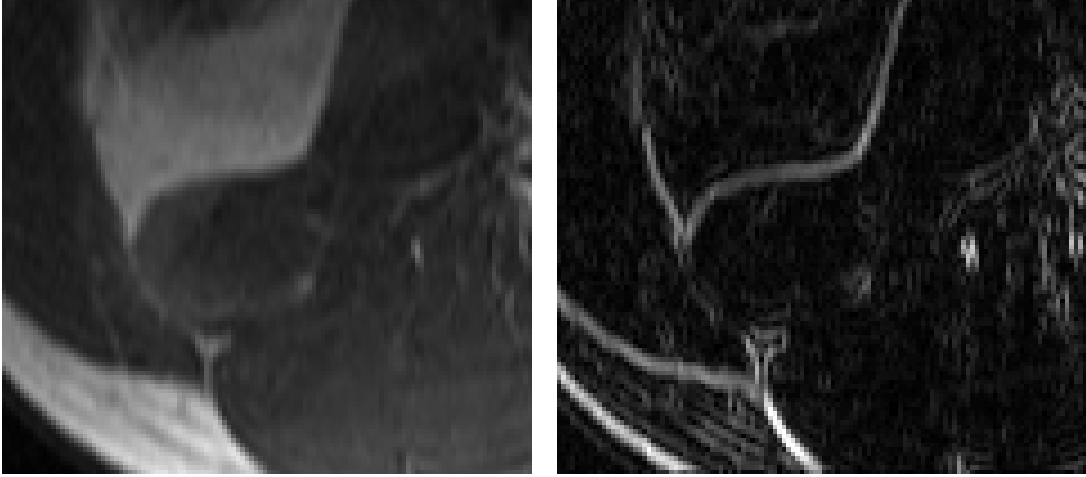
(Left) The image used in the experiment, a slice from an MRI volume. (Right) Gradient magnitude of the same image, showing the lack of contrast between the QL and adjacent muscles.
